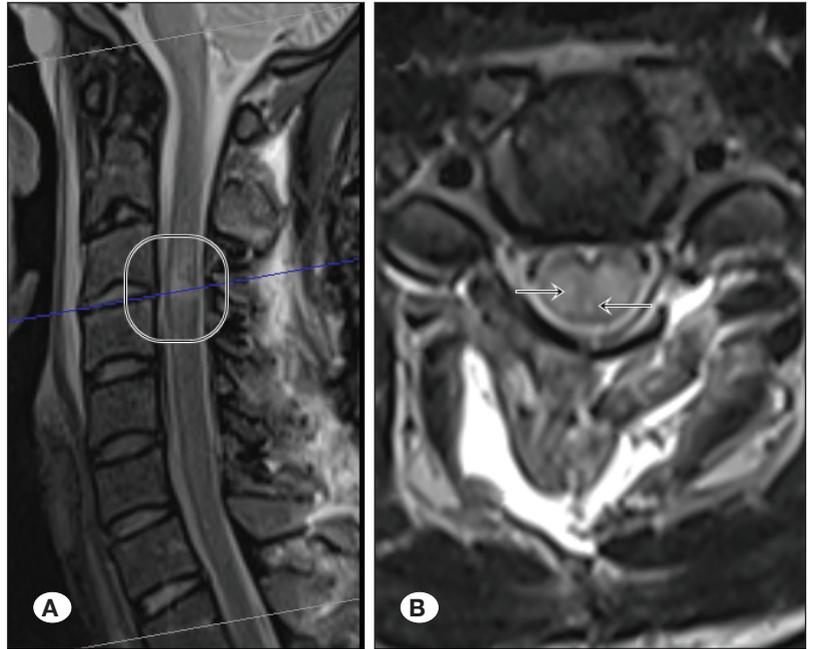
A) Cervical sagittal T2-weighted MRI high-intensity zone. B) Cervical axial T2-weighted MRI high-intensity zone (White arrow).
